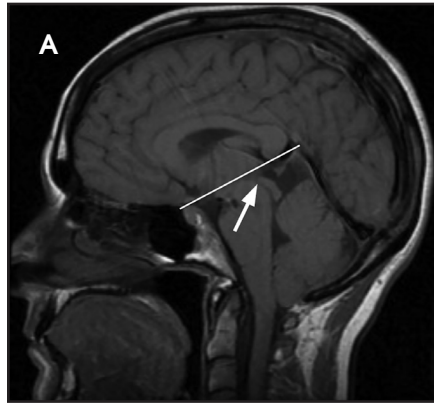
(A) Sagittal T1-weighted image demonstrating brain "sag" associated with SIH with ITER (arrow) lying inferior to incisural line. (B) Sagittal T1-weighted image of an Arnold Chiari I: Note ITER (arrow) maintains position at incisural line.
